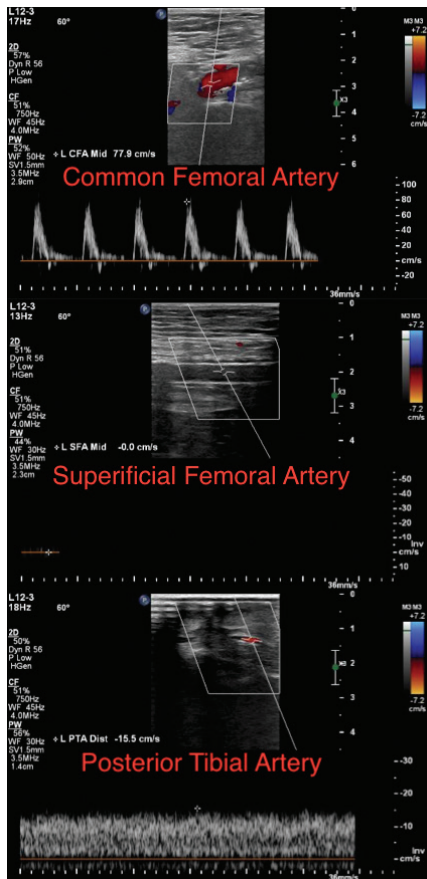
Arterial ultrasound finds triphasic waveforms in the common femoral artery, but complete loss of waveforms in the superficial femoral artery, suggesting occlusion. Downstream a monophasic waveform is present, suggesting some collateral flow feeding the posterior tibial artery.
